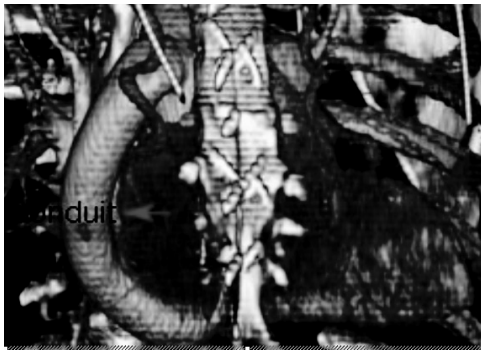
CT angiogram of the chest cavity with intravenous contrast shows the anatomical position of the conduit (indicated by a red arrow)
